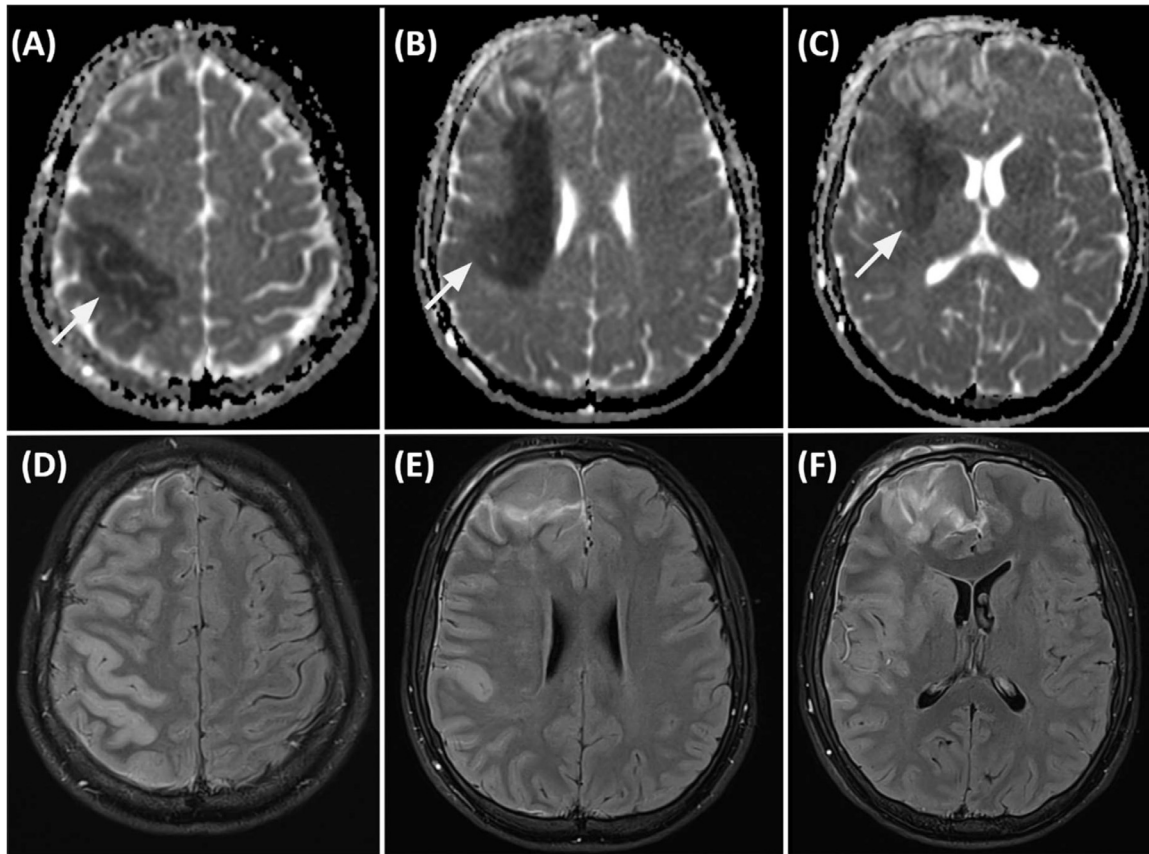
(A-C) MRI brain Axial slice with Trace ADC (apparent diffusion coefficient) mapping showing evidence of diffusion restriction (Solid white arrow). (D-F) MRI-B of the corresponding axial slice, FLAIR (fluid attenuated inverse recovery) sequence. Note the subtle hyperintensity of the right hemisphere compared to left.
